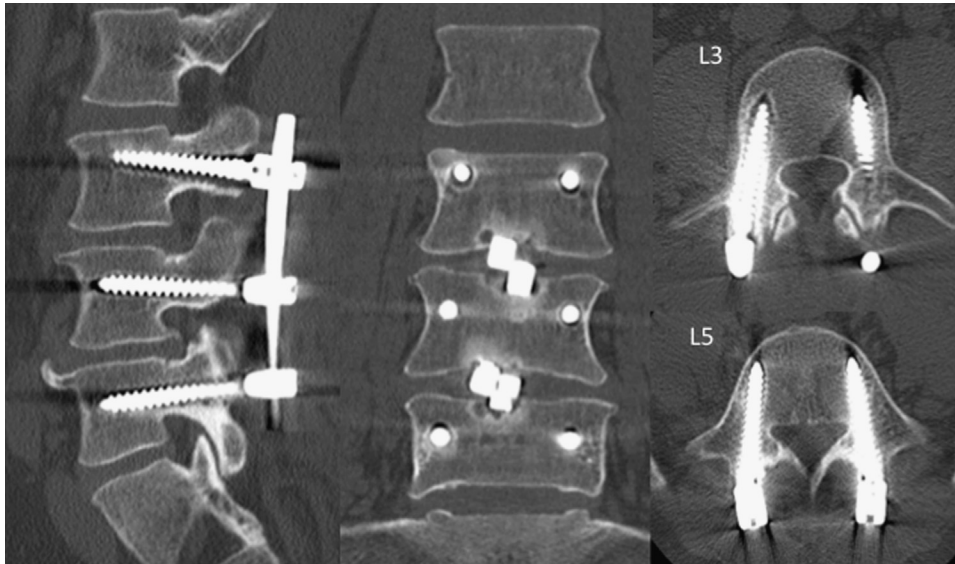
Preoperative CT demonstrating severe loosening of the pedicle screws at L3 and L5.
